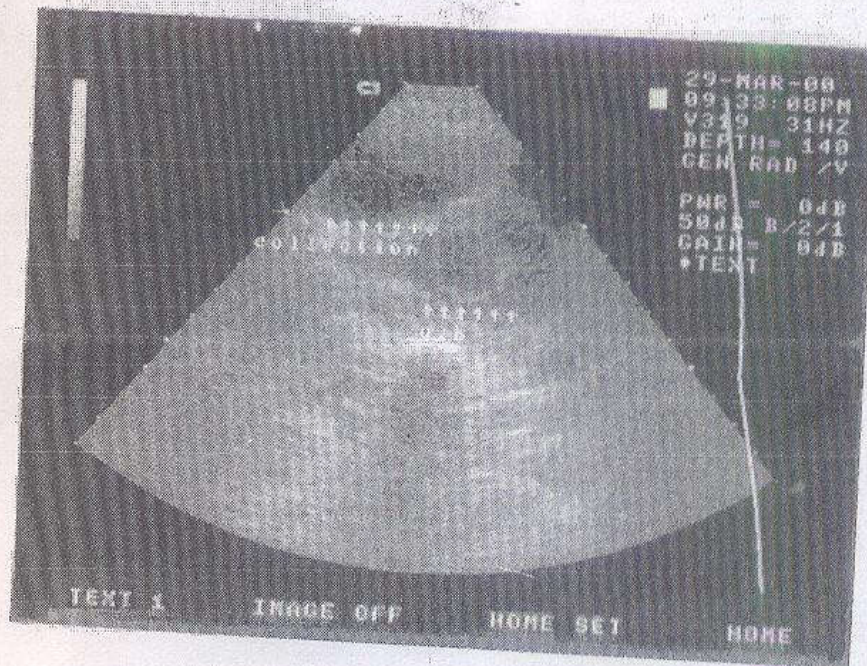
Abdominal ultrasound showed minimal pelvic collection in a female child 13 years old with plant abdominal
